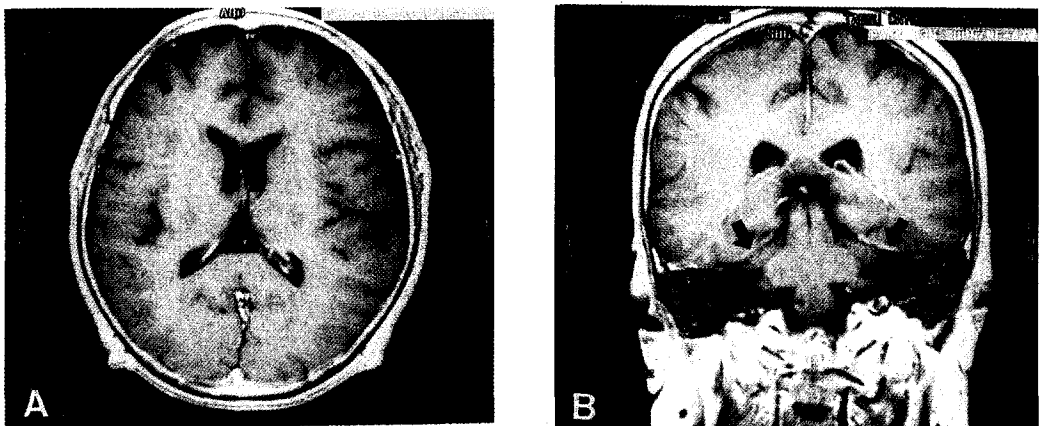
(A) Axial gadolinium-enhanced T1-weighted MRI on admission shows diffuse pachymeningeal enhancement along both cerebral hemisphere (arrows). (B) coronal plane through the posterior fossa also shows abnormal meningeal enhancement (arrows).
